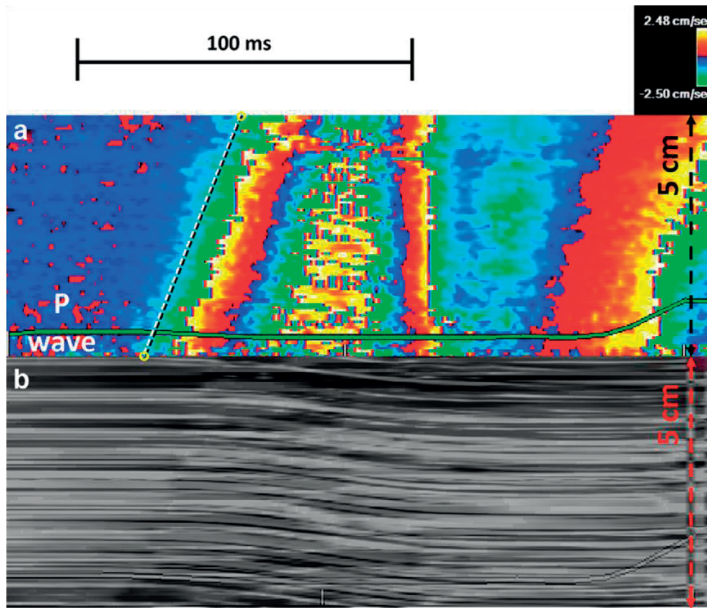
Zoomed-in view of the end-diastolic phase after atrial contraction (P wave). (a) Tissue Doppler imaging velocity pattern starting from the basal interventricular septum. In normal volunteers and some hypertrophic cardiomyopathy patients, the isovelocity front line (white dotted line) was superimposed on the black dotted line traced between the entry and exit points of the myocardial stretch post-atrial contraction (yellow circles) into the M-mode map, revealing a constant slope. (b) Synchronous anatomic M-mode of the underlying 2-D information along the same M-mode line. A progressive base-to-apex downward line shift is visible, following the same contour.
